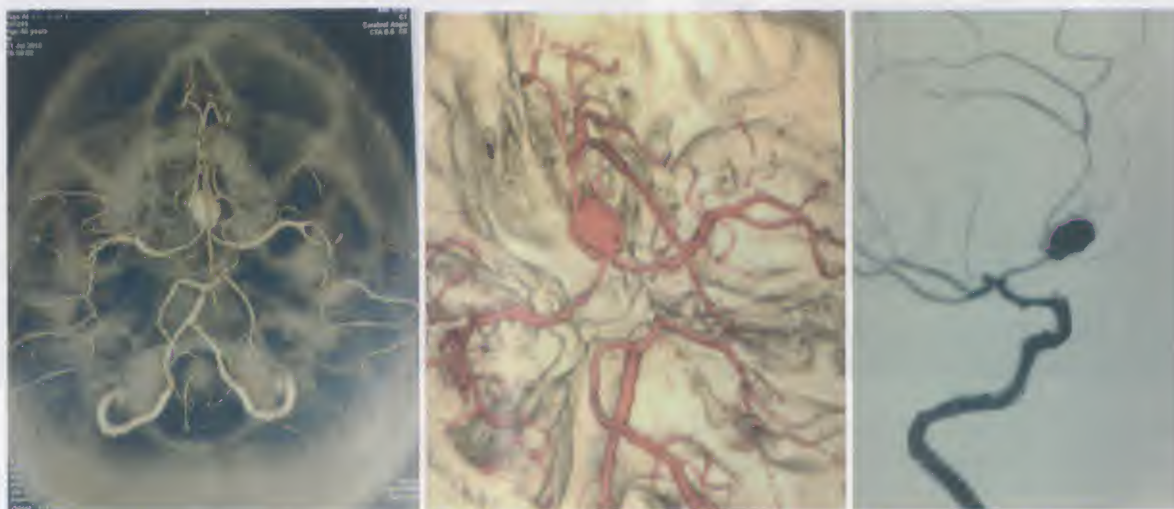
Multislice CT angiography of the cerebral vessels of a patient complaining of headache revealing a large oval shaped saccular aneurysm arising from the anterior communicating artery at the junction with the right anterior cerebral artery
